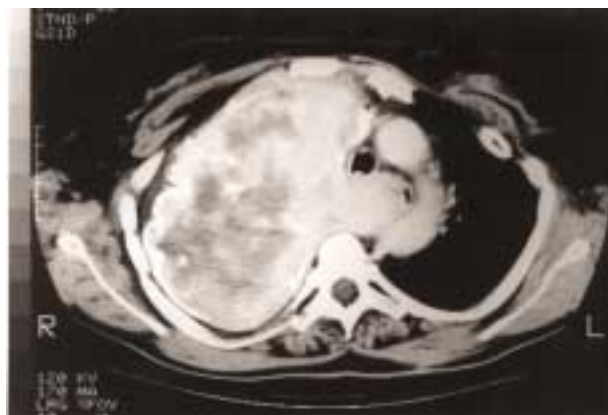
Computed tomography (CT) scan showing the solid mass that arises from the anterior part of first ribs, fills the right superior hemithorax and extends into the mediastinum, where it shifts major structures.
